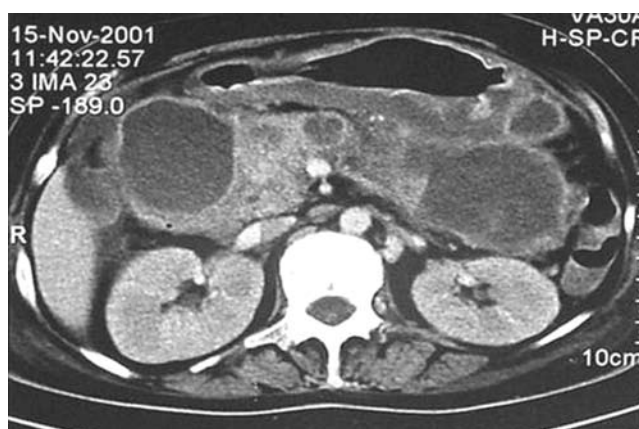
CT scan of abdomen in a case of primary hyperparathyroidism with acute pancreatitis.
